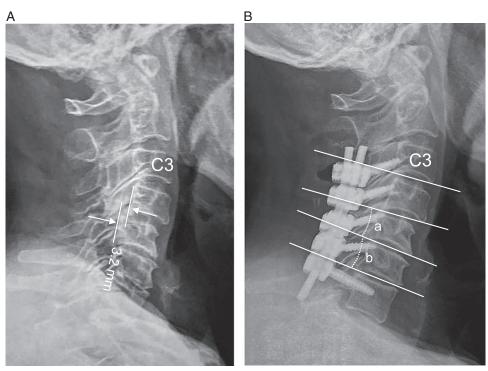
A 57-year-old with MCSM underwent a laminectomy/PF. (A): The preoperative lateral radiographs showed obvious cervical instability at C4–C5 level in this 57-year-old male with MCSM (arrows). (B): The postoperative lateral radiographs documented the laminectomy defect C3–C7 with C7 pedicle and C3–C6 lateral mass screw/rod fixation.
